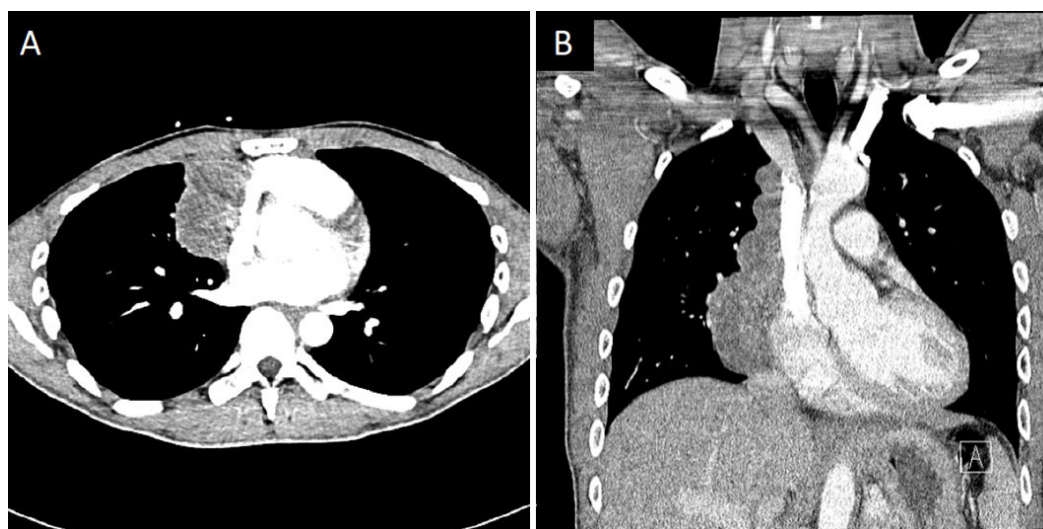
Computed tomography chest showing large right mediastinal mass. Contrast-enhanced computed tomography images (A: axial; B: coronal), showing a large multilobulated right anterior mediastinal mass measuring 6.0 cm × 4.7 cm in transverse dimension by approximately 13 cm in craniocaudal dimension. There was found to be mass effect with mild compression of the right atrium and superior vena cava (though patent). Thymoma was suspected, and proven later on biopsy
